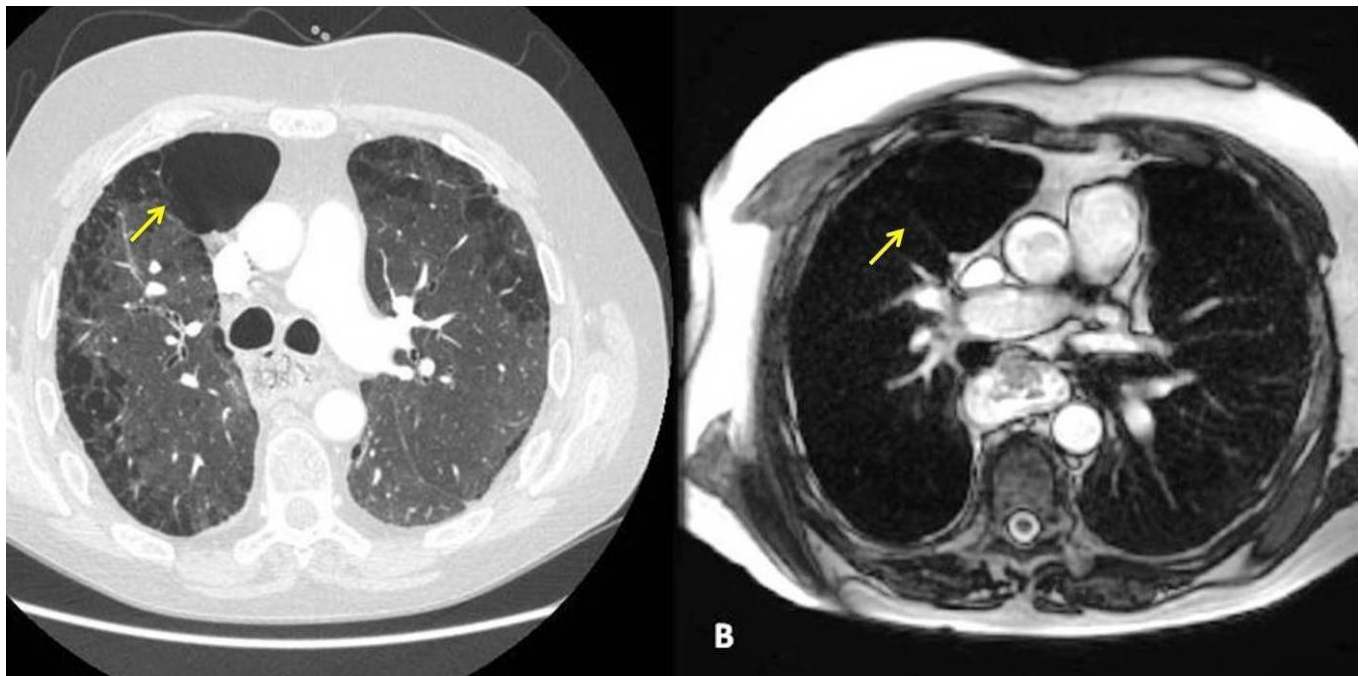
A peripheral bulla in the right middle lobe is appreciated on MRI
